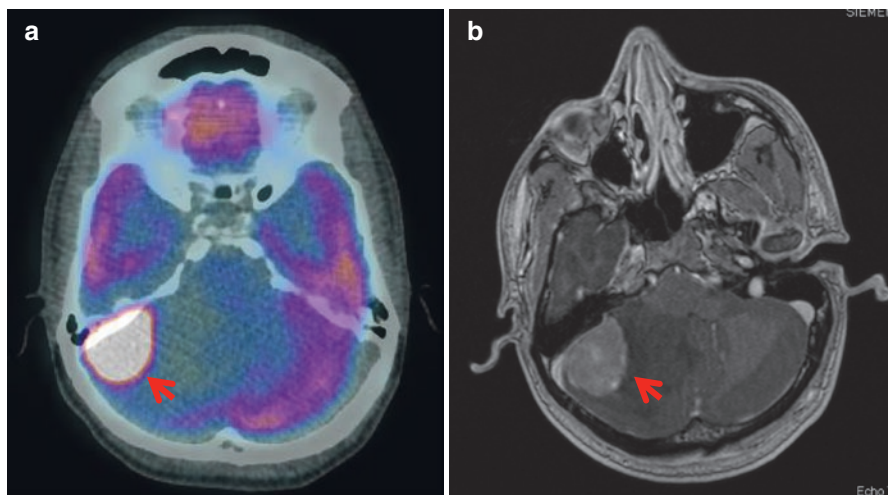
(a, b) Patient with previous lymphoma completed chemotherapy 2 months ago and presented with cerebellar signs, and MRI showed a right cerebellar mass. Axial fused ^{18}F FDG PET/CT (a) and post-contrast T1WI (b) show intensely avid right cerebellar lesion (a, arrow) corresponding to the enhancing lesion (b, arrow), in keeping with relapsed CNS lymphoma. Teaching point: Given the usual intense ^{18}F FDG uptake in lymphoma, evaluation of areas with usually high metabolic activity like the brain is possible, and evaluation with FDG PET/CT is particularly useful in assessing disease relapse in patients with prior history of lymphoma
